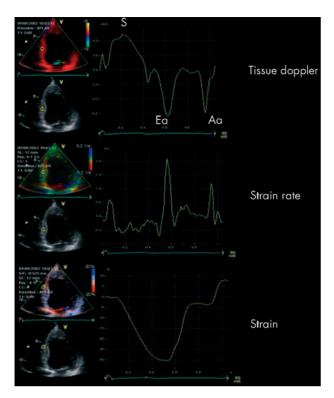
Tissue Doppler echocardiography (TDE), strain rate, and strain profiles of a normal subject obtained from an apical four chamber view. Time is on the horizontal axis. The region of interest is located in the mid inferoseptal segment. The TDE waveform consists of a first positive wave during the pre-ejection period, a systolic inward wall motion (S), followed by the isovolumic relaxation waves and by the outward wall motions Ea and Aa related to ventricular filling. Longitudinal strain rate profile is obtained from the same region of interest during the same cardiac cycle and shows corresponding waves. Negative systolic strain indicates longitudinal compression.
